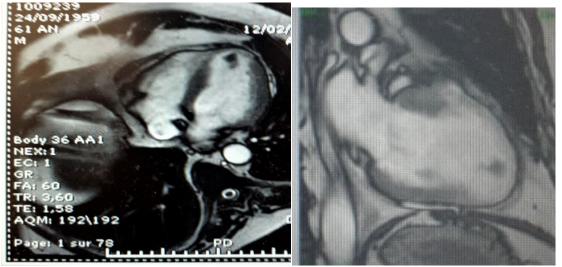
MRI showing two thrombus, A) apical thrombus, B) thrombus in the median anteroseptal wall
